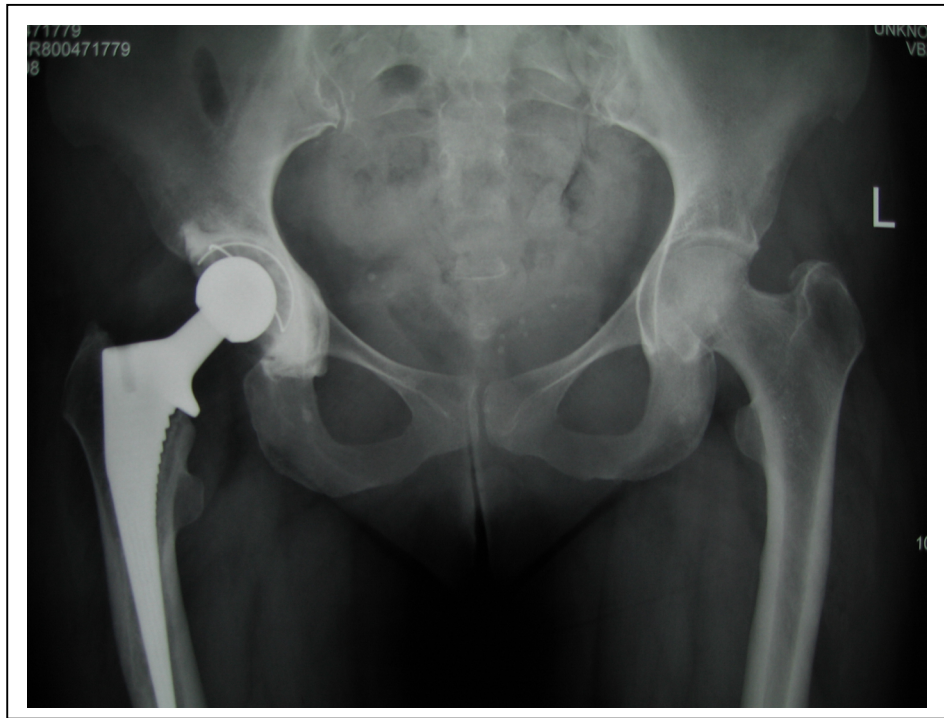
radiograph of a total hip replacement where the femoral stem is too long resulting in a type 1 true leg length inequality.
